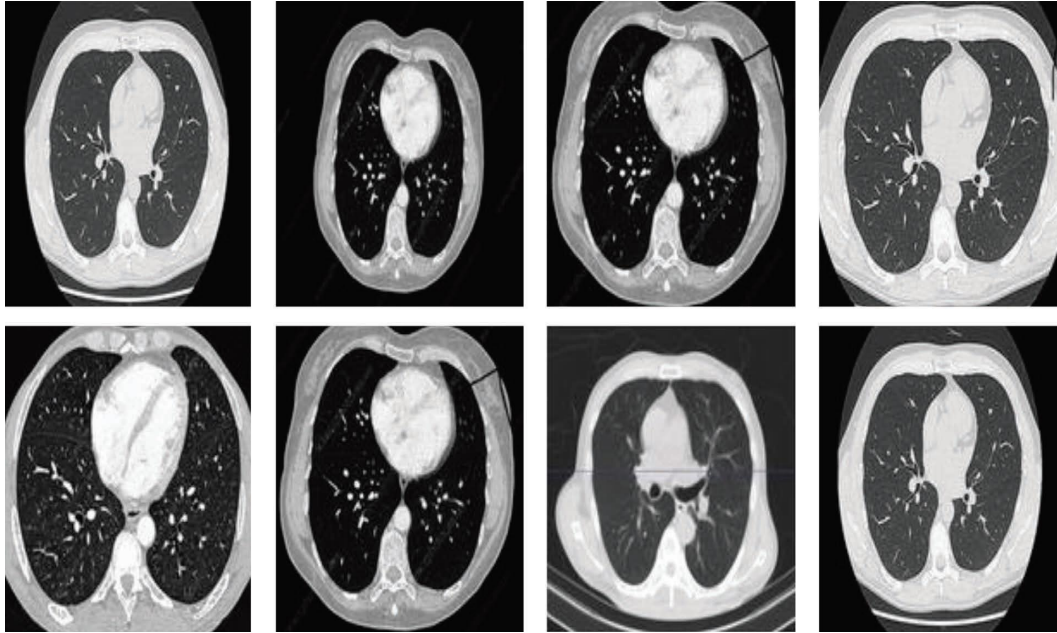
Chest-CT scan images (source: kaggle).
